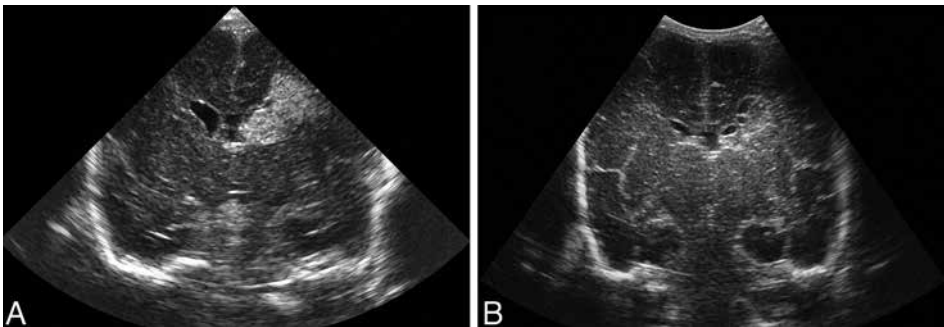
Coronal ultrasound scans in very preterm infant (gestational age 27 wk) with intraventricular hemorrhage, complicated by periventricular hemorrhagic infarction (PVHI). (A) The PVHI is presented by a large echogenic lesion in the frontal white matter, ipsilateral to the intraventricular hemorrhage. (B) End stage PVHI, presented by cystic lesions in the previously echogenic area.
